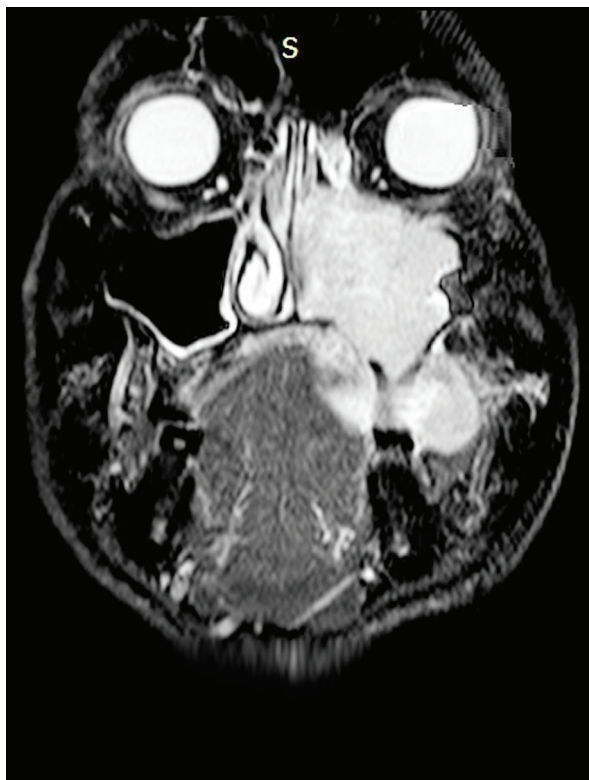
Axial MRI of the lesion showing a large invasive sinonasal mass centred in the left maxillary antrum.
